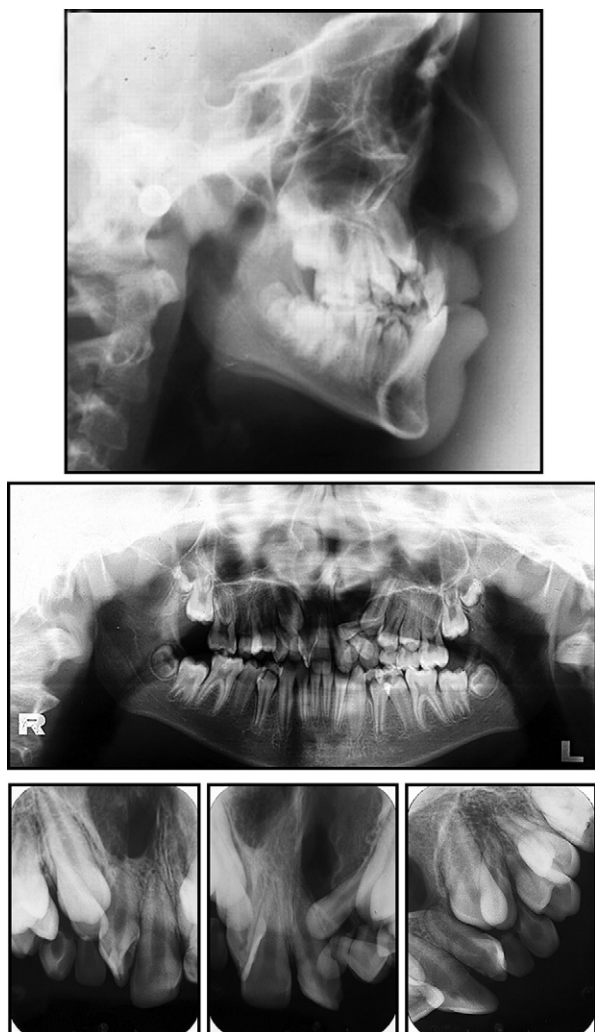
Pretreatment cephalometric, panoramic, and periapical radiographs.
